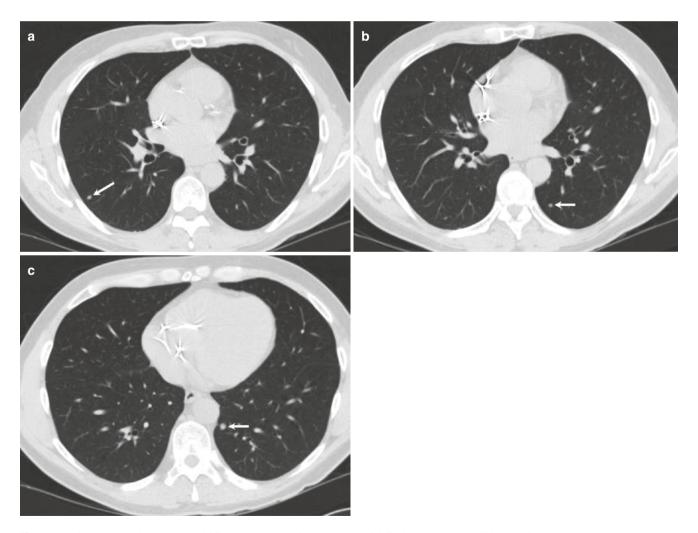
Blastomycosis in a 55-year-old liver transplant recipient. (a-c) Axial CT images show small lung nodules (white arrows)
